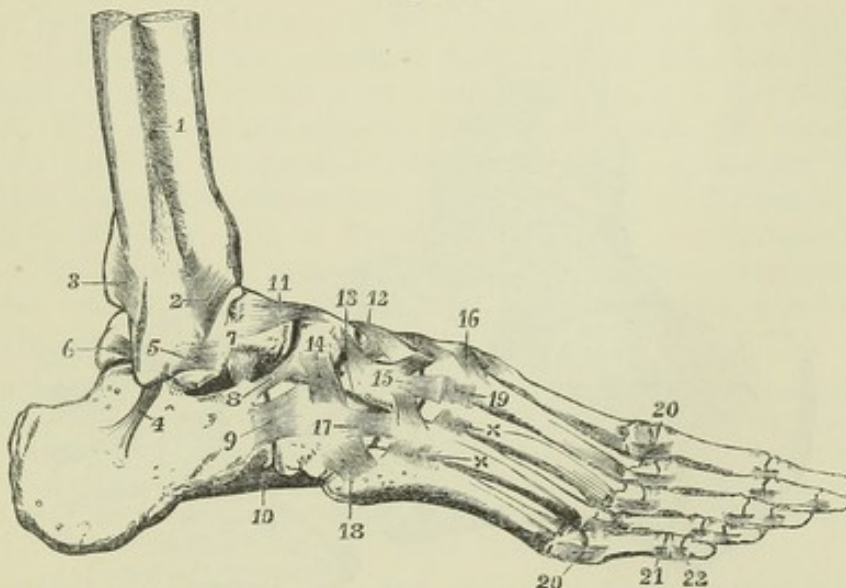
LIGAMENTS OF THE FOOT, FROM THE OUTSIDE AND DORSAL ASPECT.  $\frac{1}{2}$
